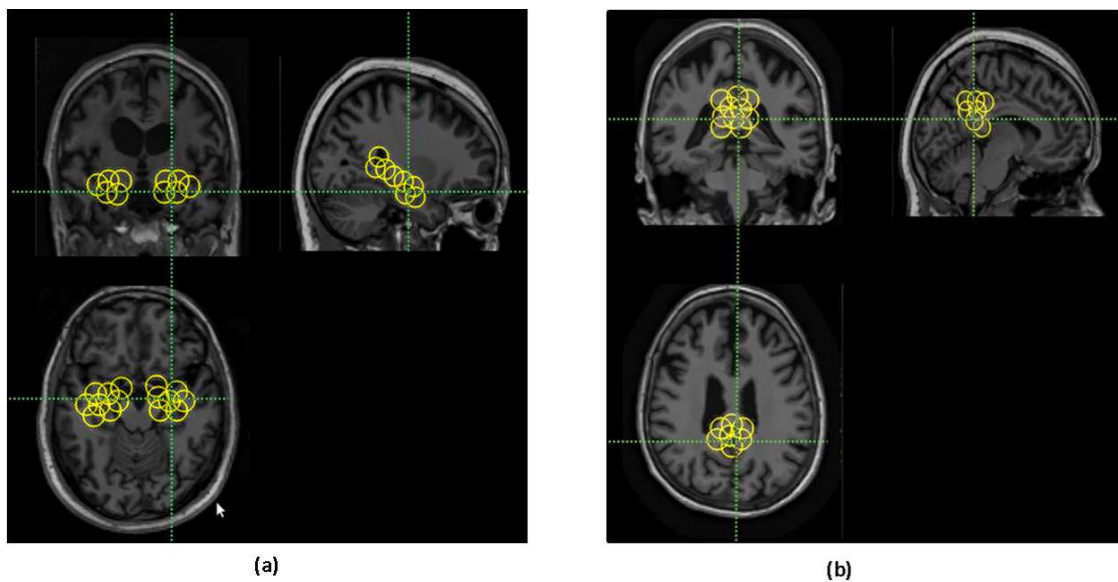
CHF Keypoints detection on MRI brain : Example of dense placement of local features on brain scans of a subject from the ADNI dataset. Extracted local feature is the descriptor of a circular support area, defined by each point of the grid and the radius of the support area in the ROI. (a) descriptors extraction of the hippocampus ROI (sagittal, coronal and axial projections), (b) descriptors extraction on the PCC ROI (sagittal coronal and axial projections). Here, CHF captures the image variations and extract local visual features of each ROI.
